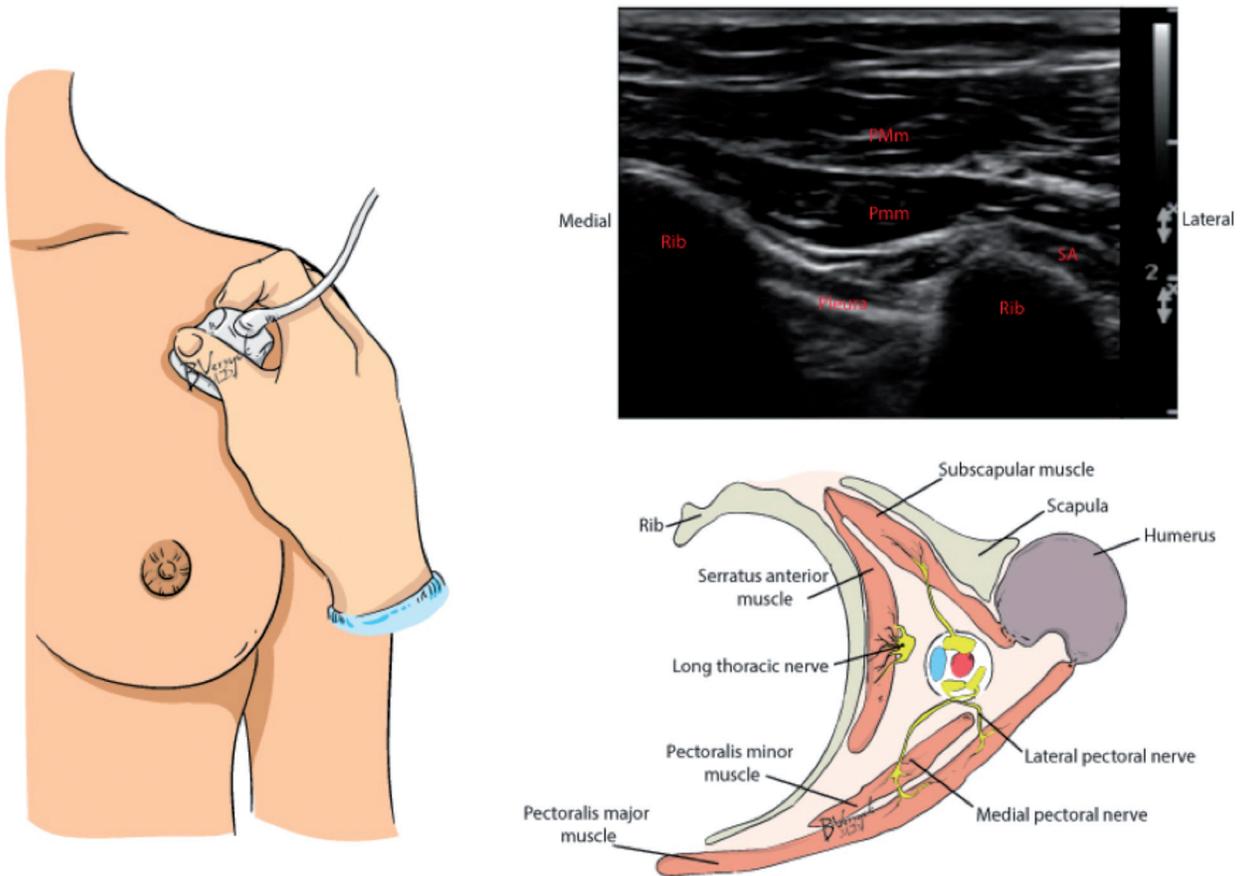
Positioning of ultrasound probe and the corresponding ultrasound image and cross-sectional anatomy.
